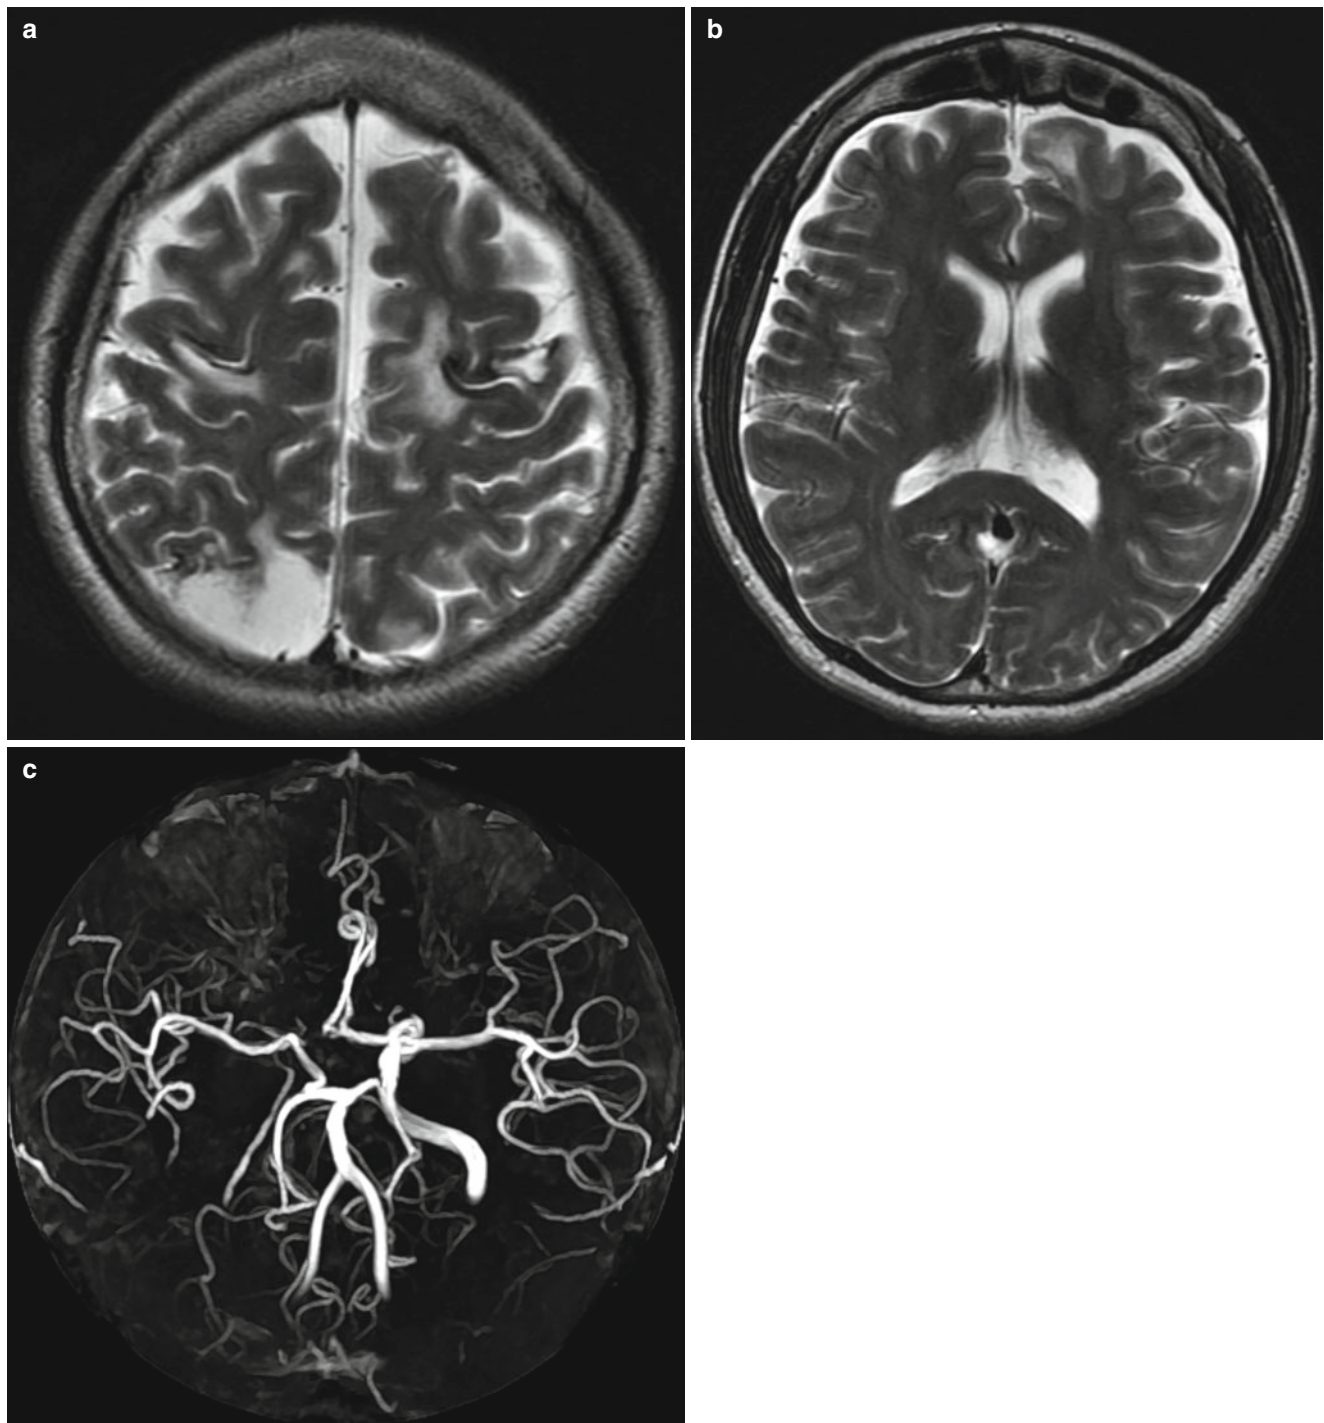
Homocystinuria in a 24-year-old female patient with seizures and stroke. (a, b) T2-weighted image shows multifocal encephalomalacia with focal hemosiderin deposits suggesting old hemorrhagic
